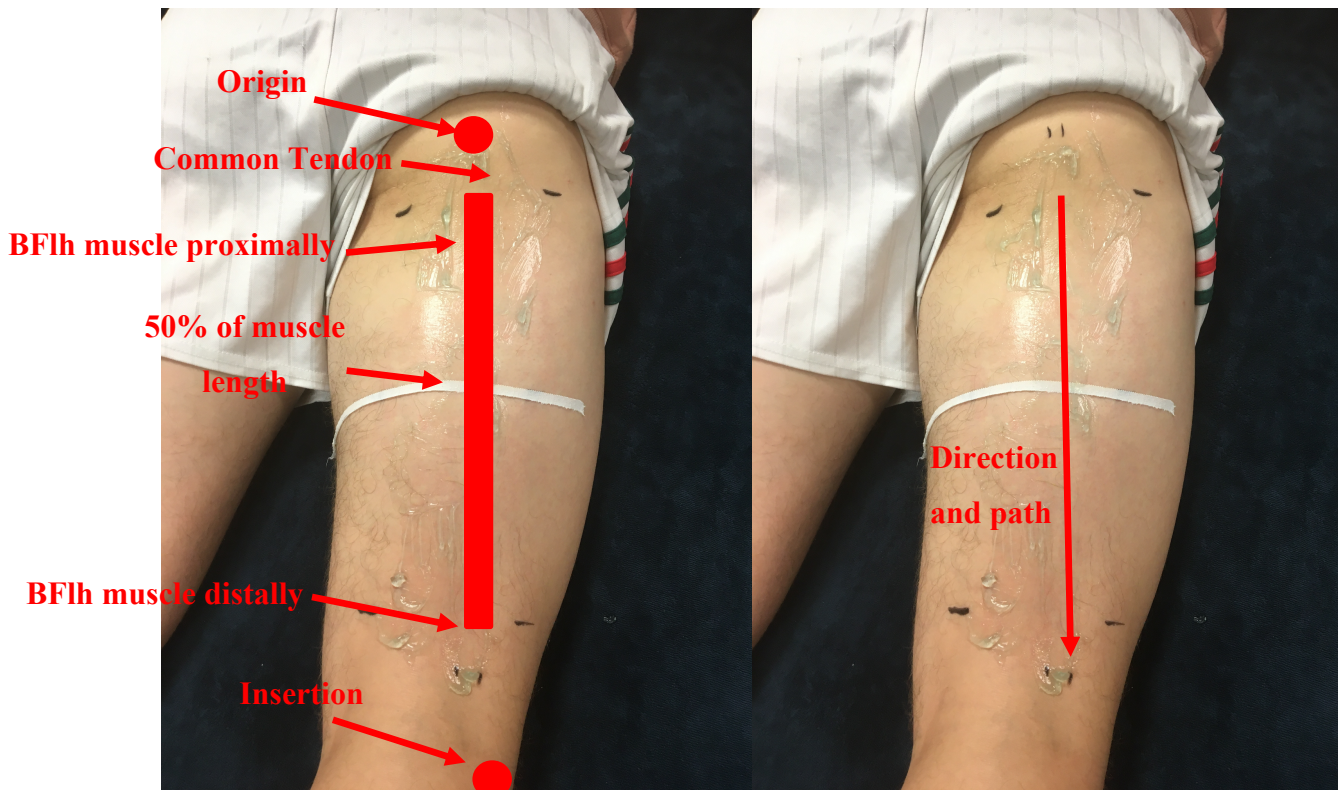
1: *Details of BFLh Anatomy and surface preparation for ultrasound scan.*
